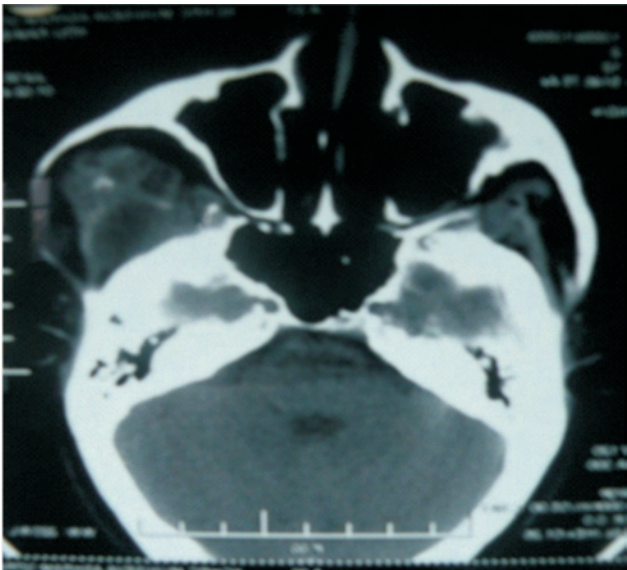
CT Scan Axial View
